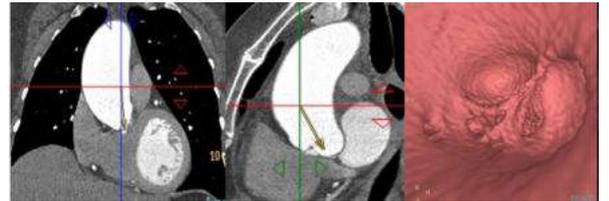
(A-C). CT Aortic angiogram reformatted coronal (A), sagittal (B) and virtual angiography (C) images reveal a thickened aortic valve causing mild aortic stenosis.
